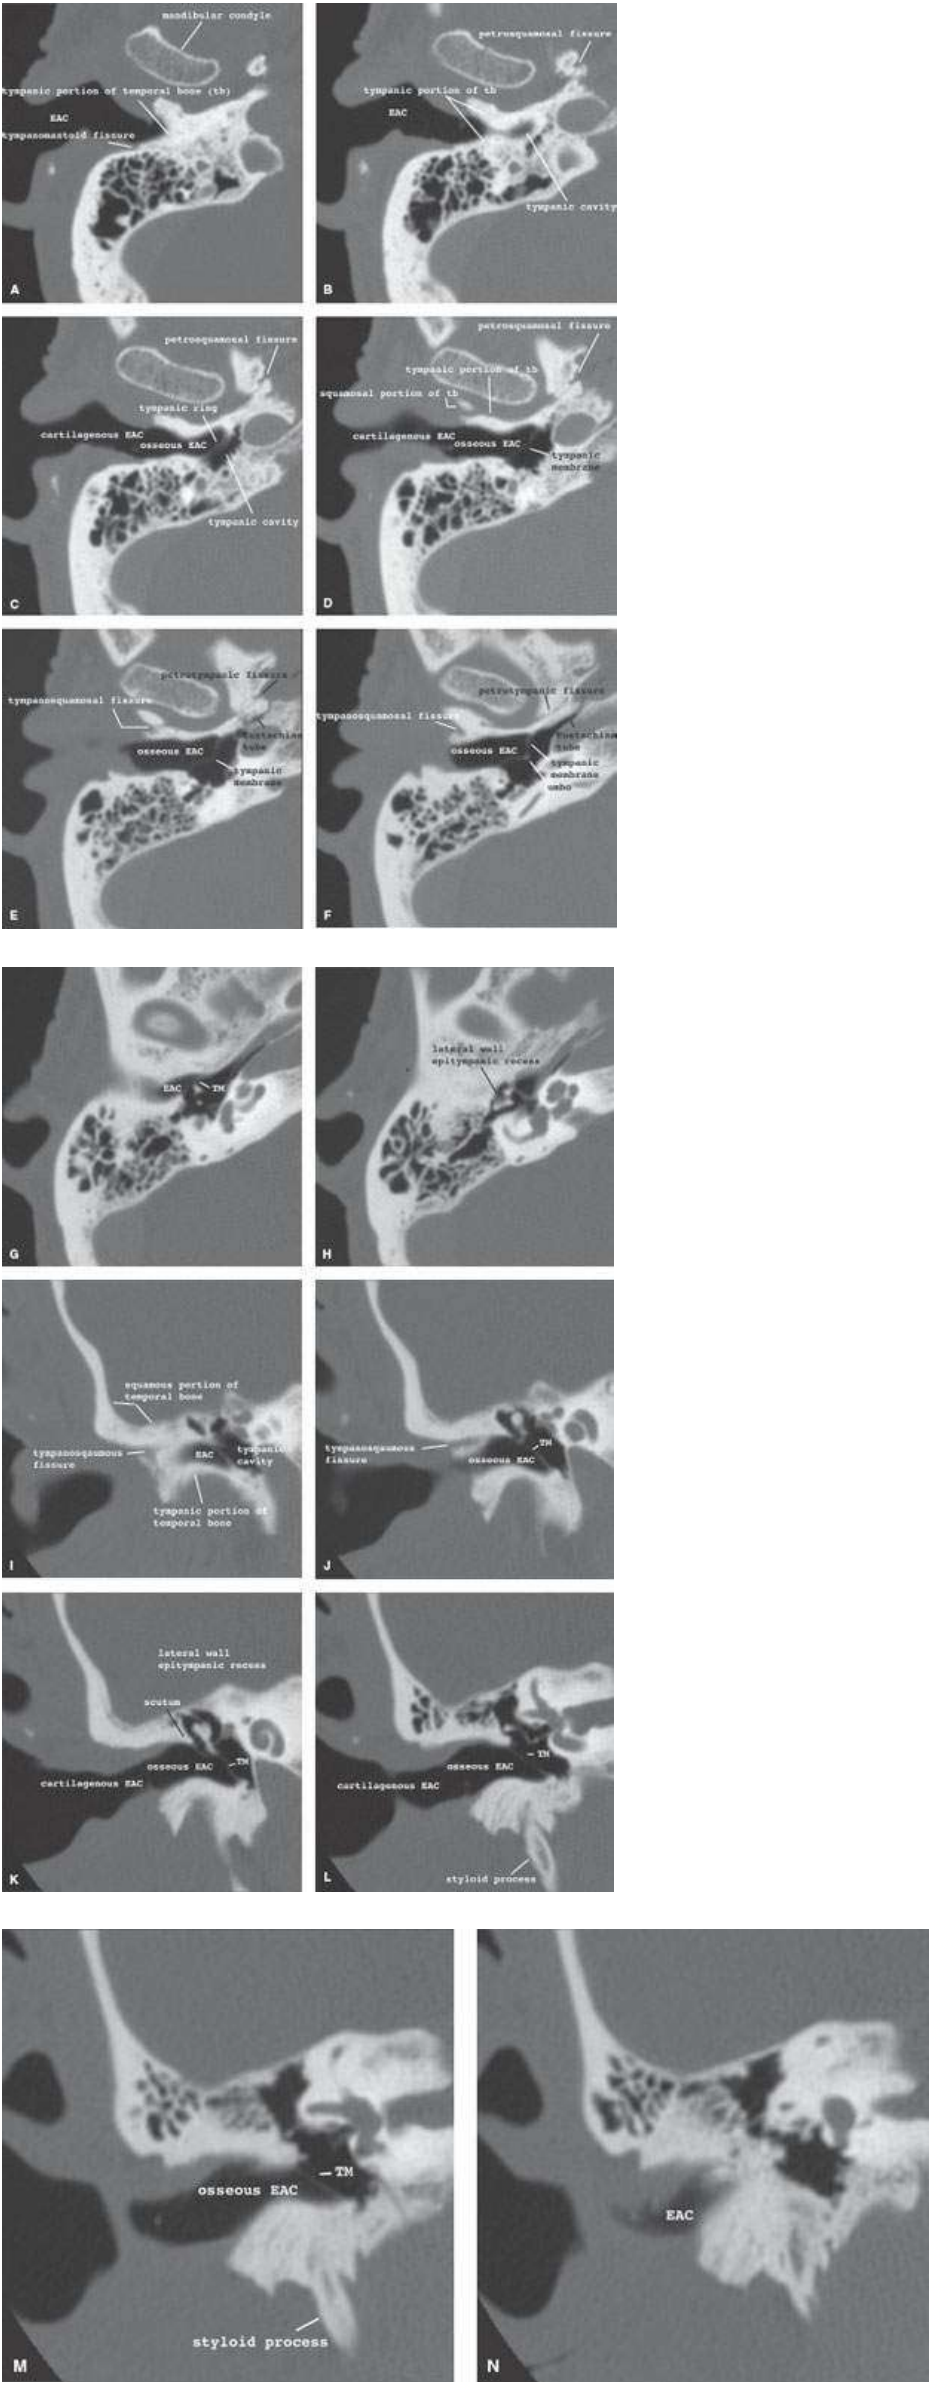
Normal anatomy of the external auditory canal on axial (A–H) and coronal (I–N) computed tomography images.
